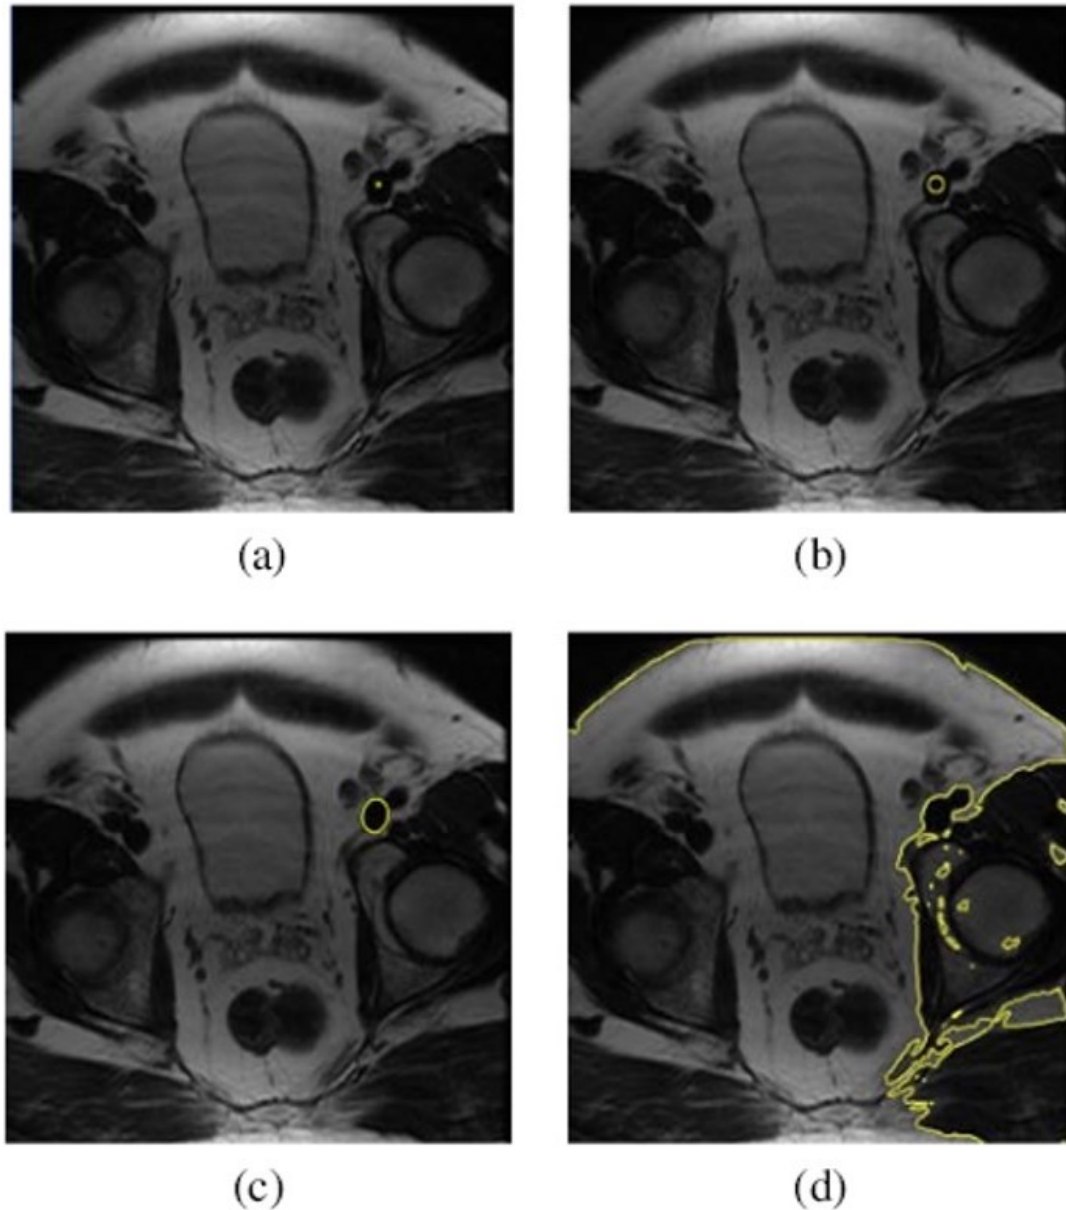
An example showing the results of elliptical prior used by Slabaugh and Unal to find a blood vessel in a pelvic MRI image. (a) shows the user clicks yellow (b) shows the evolution of the ellipse until (c) where it achieves the segmentation. (d) shows the result of the segmentation without the elliptical prior. Graph Cut included all the regions which had the same pixel characteristics as the region of interest
